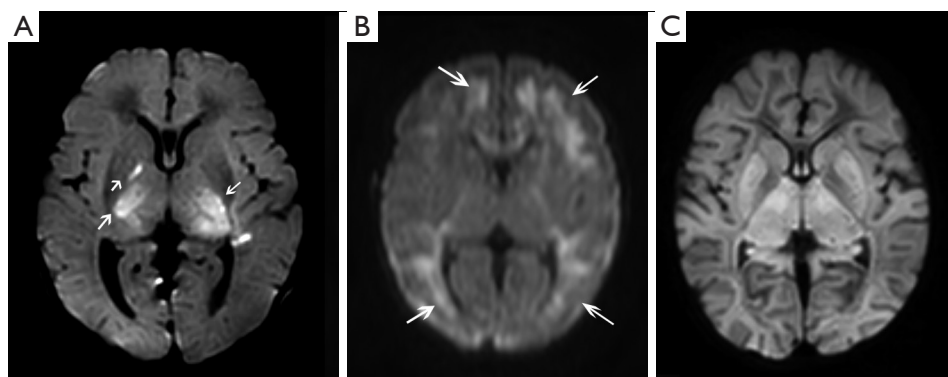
Axial diffusion weighted magnetic resonance images (DWI) showing 3 different patterns of brain damage i.e., acute, subacute, and severe global, respectively. (A) Basal ganglia/thalamus type of injury: DWI image on day 4 shows an increased signal in the basal ganglia and thalamus (see arrows) indicating brain damage after an acute perinatal hypoxic-ischemic insult. (B) Watershed type of injury: DWI image on day 5 shows increased signals in the “watershed” areas of the anterior, middle and posterior cerebral arteries indicating damage in these regions after subacute perinatal hypoxia-ischemia. (C) ‘Near total’ type of injury: DWI image on day 5 after very severe perinatal hypoxia-ischemia showing signal changes in the entire brain indicating severe global brain damage.
